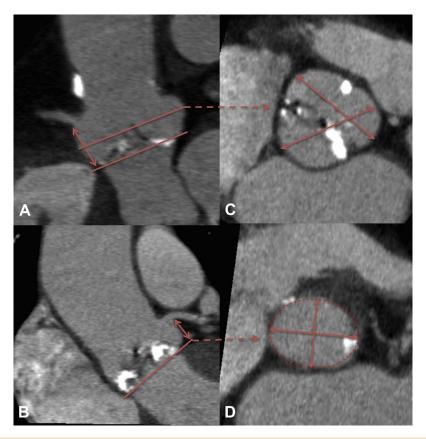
Multidetector CT Evaluation Pre-TAVI
